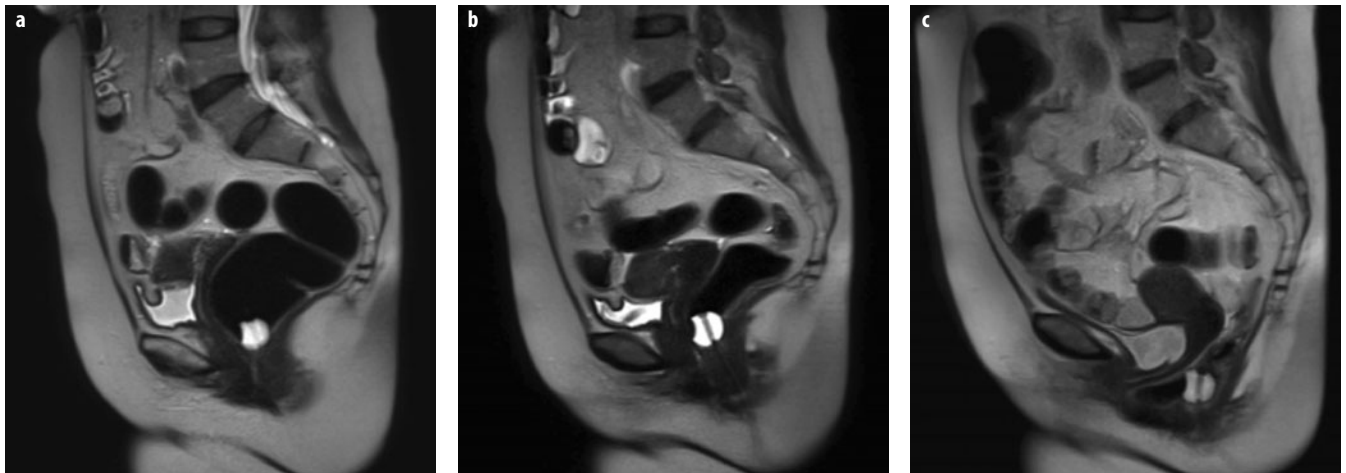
a-c. Anorectal angle (ARA) variations. a Sagittal T2-weighted image at rest after rectal distension with air through a balloon Foley catheter. At rest, the ARA is approximately 90°. The anorectal junction (ARJ) corresponds to the balloon filled with fluid. b Sagittal T2-weighted image during contraction of the pelvic floor: the ARA reduces to <90°. c In this patient with obstructed defecation syndrome (ODS), during straining, the ARA opens >130° due to the rectal prolapse (>160°) and is associated with severe ARJ prolapse (>6 cm), cystocele, and colpocele. An anterior rectocele with rectal invagination is also visible
